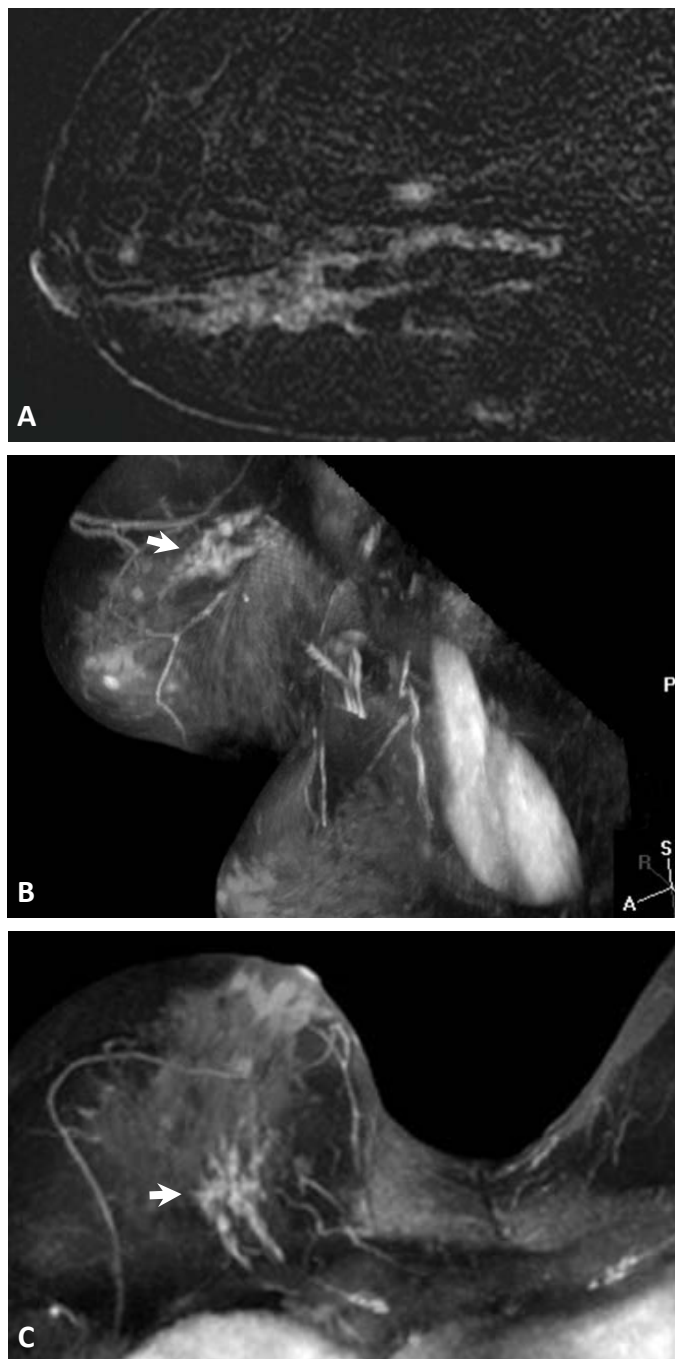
Clumped non-mass-like enhancement (NMLE) of high-grade DCIS. (A) Sagittal MR post-contrast subtraction image shows clumped, segmentally distributed NMLE in the mid to lower breast. (B) Craniocaudal and (C) axial post-contrast MIP images in a different patient with mammographically occult high-grade DCIS reveal asymmetric, clumped segmental enhancement (white arrows) in the upper inner breast. The orientation of the affected breast was positional, as it did not persist on the subsequent MRI guided biopsy.
